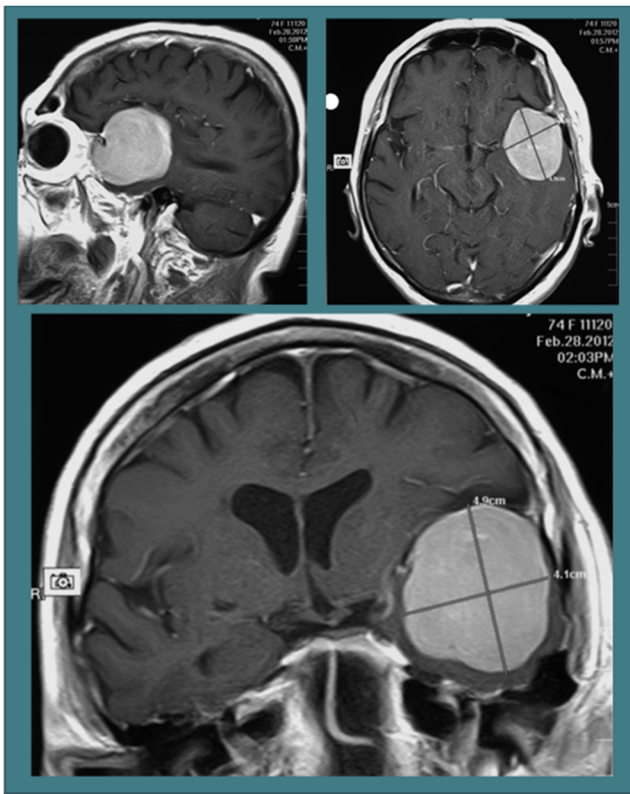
Case 20. Preoperative MRI with contrast enhancement
